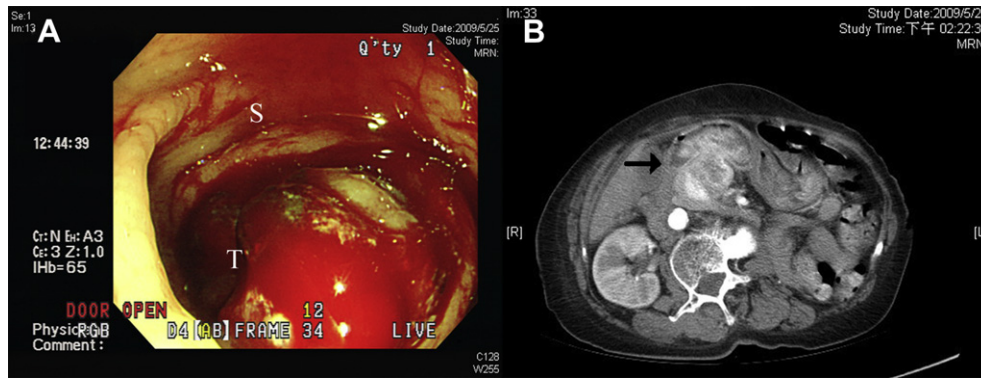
(A) Esophagogastroduodenal endoscopy: a large submucosal mass lesion (T) with active bleeding was found involving the distal stomach (S) and proximal duodenum. (B) Contrast-enhanced computed tomographic scan: a large hypervascular mass lesion (black arrow) occupies the distal stomach, proximal duodenum, and pancreatic head.
